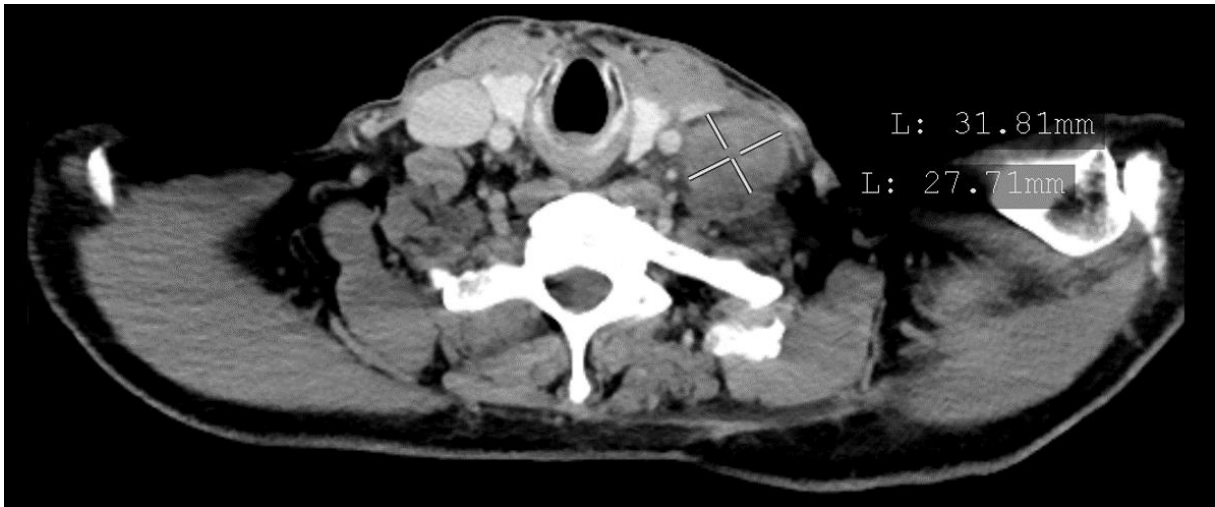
Initial CT scan revealing a left cervical lymph node metastasis.
